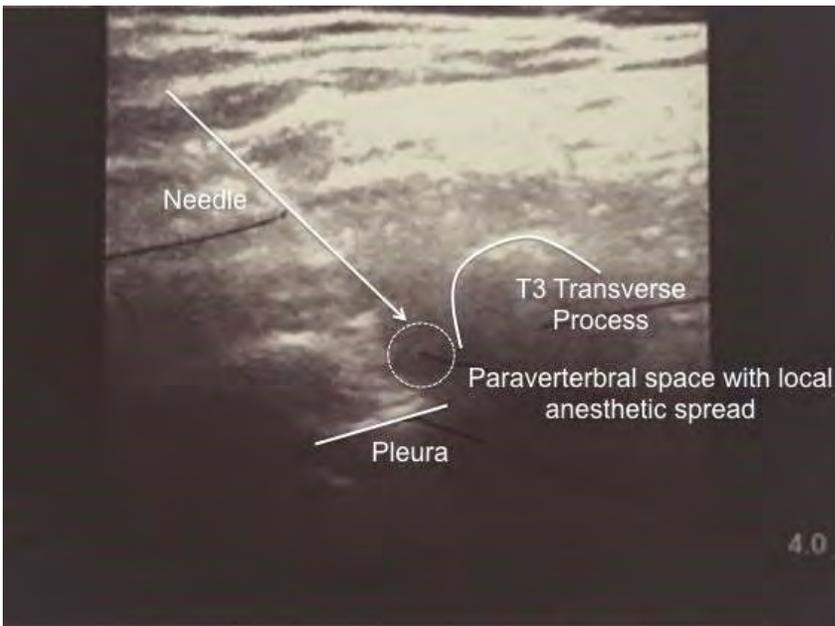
Ultrasound image of local anesthetic injection into the left T3 paravertebral space.
